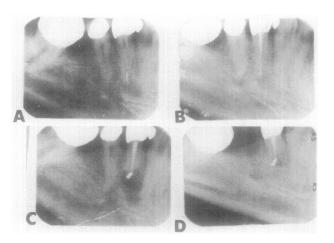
Case 7. Mandibular left first premolar of 38year-old white man. A, Preoperative radiograph showing split-cone technique of root canal therapy with silver cone in apical one fourth and poorly condensed gutta-percha in remaining canal. Treatment was performed 2 years previously by general dentist. Patient now has apical bone loss, severe pain, and percussion sensitivity. An attempt, during conventional retreatment, to bypass and remove the silver cone was unsuccessful. B, Radiograph showing root canal occlusal to silver cones instrumented and refilled with gutta-percha. C, Patient continues to have pain and percussion tenderness, so surgery is indicated. Immediate postoperative radiograph shows retrograde amalgam at root apex. Note removal of apical one fourth of root that contained silver cone. D, Recall radiograph 5 years later shows asymptomatic tooth with apical bony regeneration.
